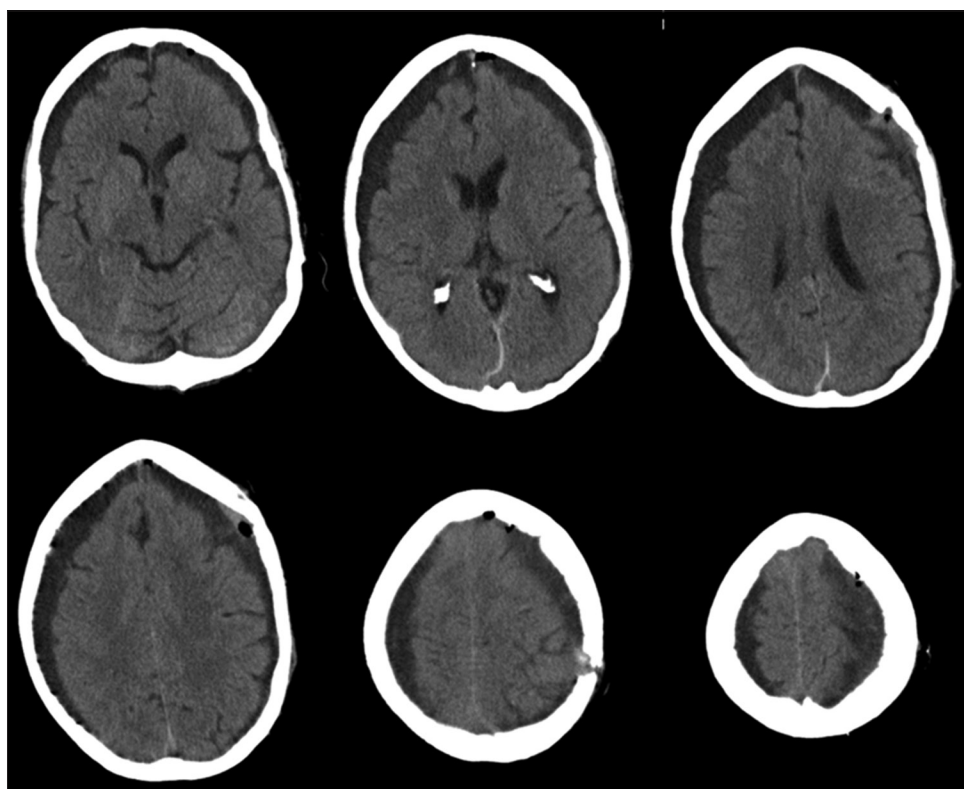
CT head postsecond drainage. Reaccumulation of subdural collection on left hand side and stable collection on the right side
